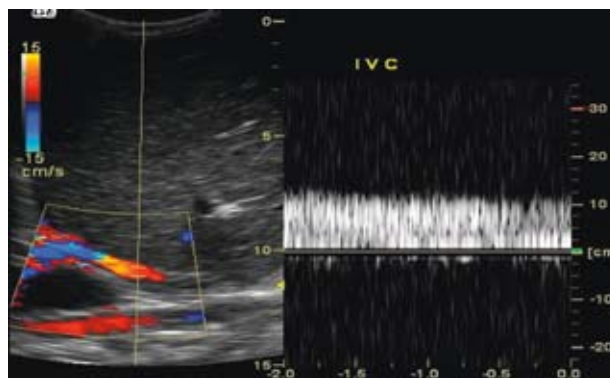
Inferior vena cava obstruction on color Doppler
